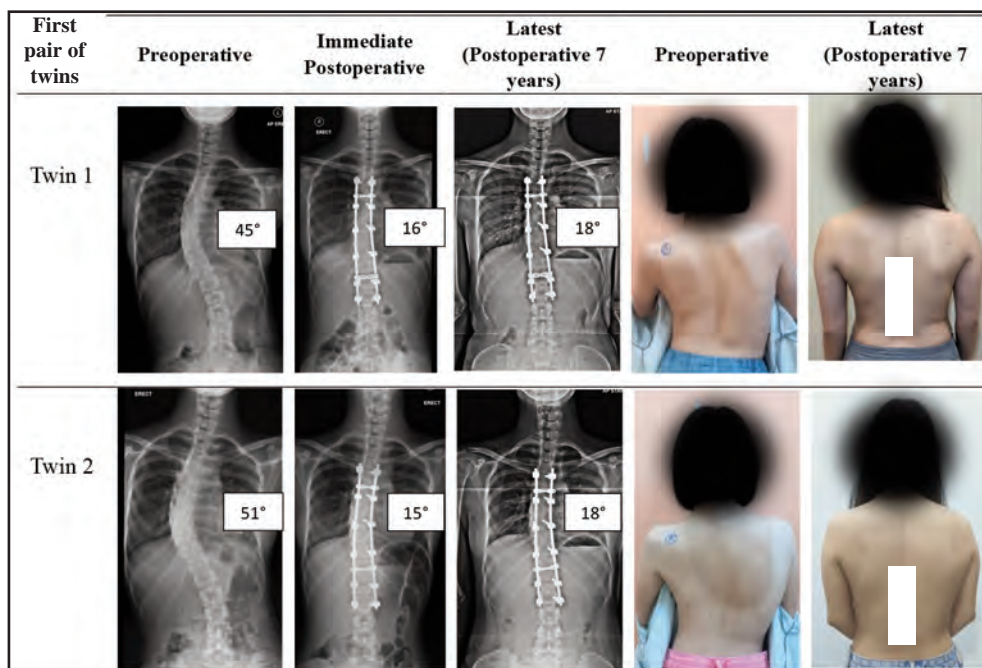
Preoperative radiographs, immediate postoperative radiographs, latest follow-up radiographs, preoperative clinical photographs and latest postoperative clinical photographs of the first pair of twins.
